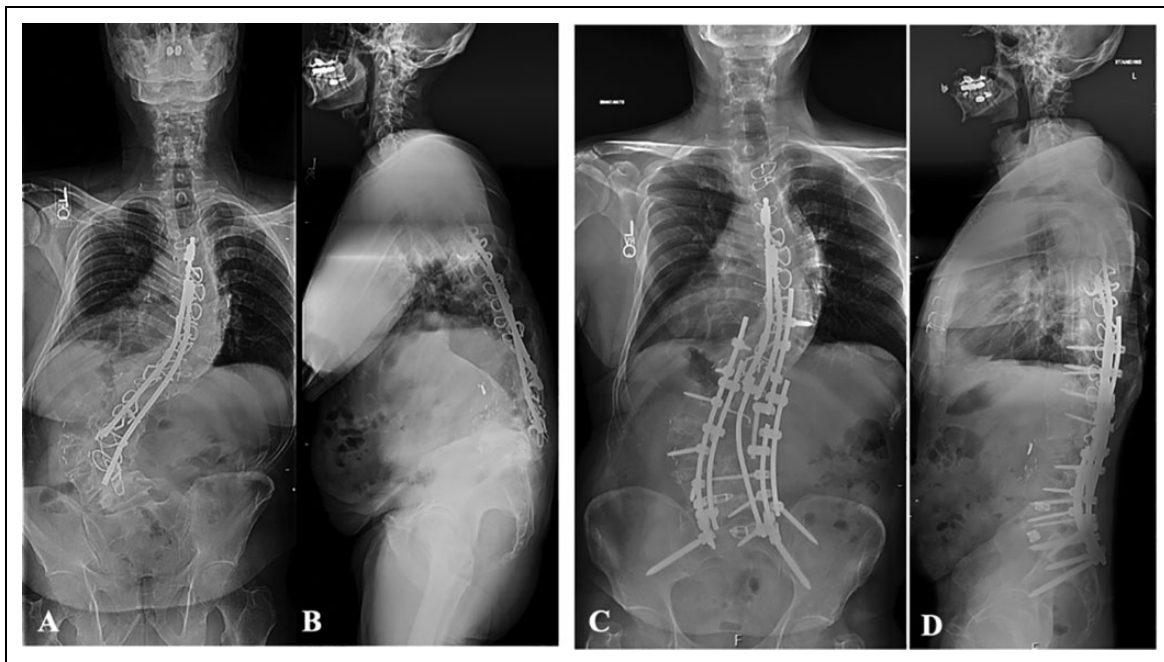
A 71-year old male who presented with chronic low back pain numbness/tingling in his bilateral legs and feet 31 years following Harrington rod instrumentation for idiopathic scoliosis. Preoperative anteroposterior (A) and lateral plain radiographs (B) of the full spine reveal Harrington rod instrumentation with a caudal hook at L4 in the setting of a right coronal shift, positive sagittal balance, and loss of lordosis. He subsequently underwent a single-staged T8-pelvis posterior spinal fusion with a left asymmetric pedicle subtraction osteotomy performed at the L4 level and a transforaminal lumbar interbody fusion at L4-5 (C, D) with restoration of his lumbar lordosis and improvement in her overall sagittal alignment. His symptoms remain significantly improved 14 months after the revision procedure.
